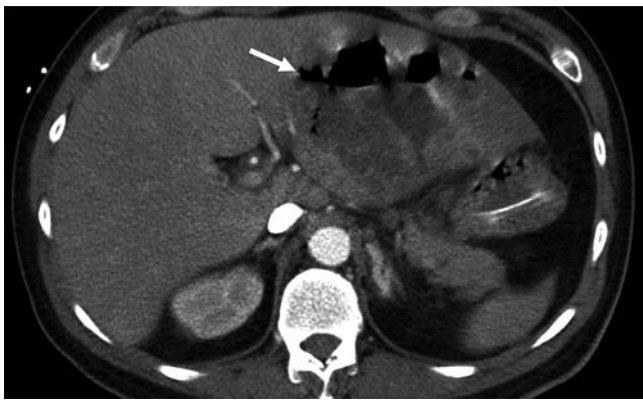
Contrast-enhanced abdominal CT showed a large (11.2 cm diameter) liver abscess (arrow) in the left lateral segment of the liver with an internal air-fluid level.
